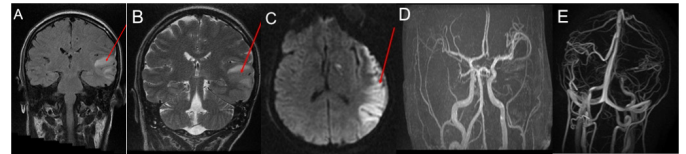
Brain MRI showing left parieto-temporal demyelinating lesion with cortical and sub-cortical increased signal intensity on FLAIR (A), T2 (B) and diffusion (C) weighted images (arrows). Angio MRI is normal (D + E).
